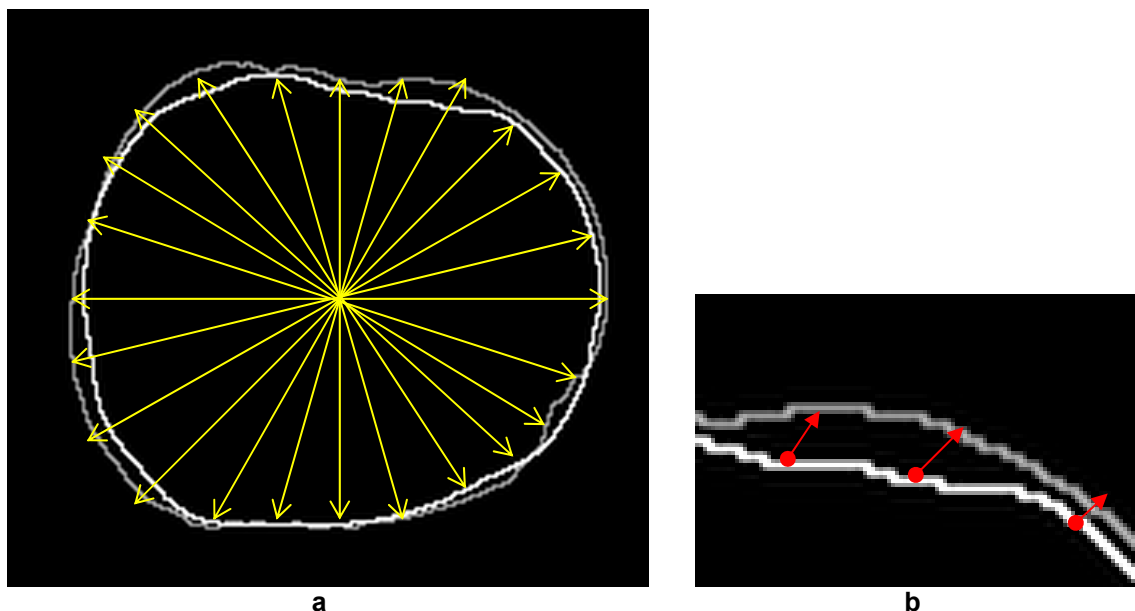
a. Definition of corresponding points on the surfaces of the moving and the target images. Gray: CT (PET) surface, White: MRI surface. b. Partial zoomed view of displacement vectors obtained for previously defined (left panel) corresponding points on the surfaces.
